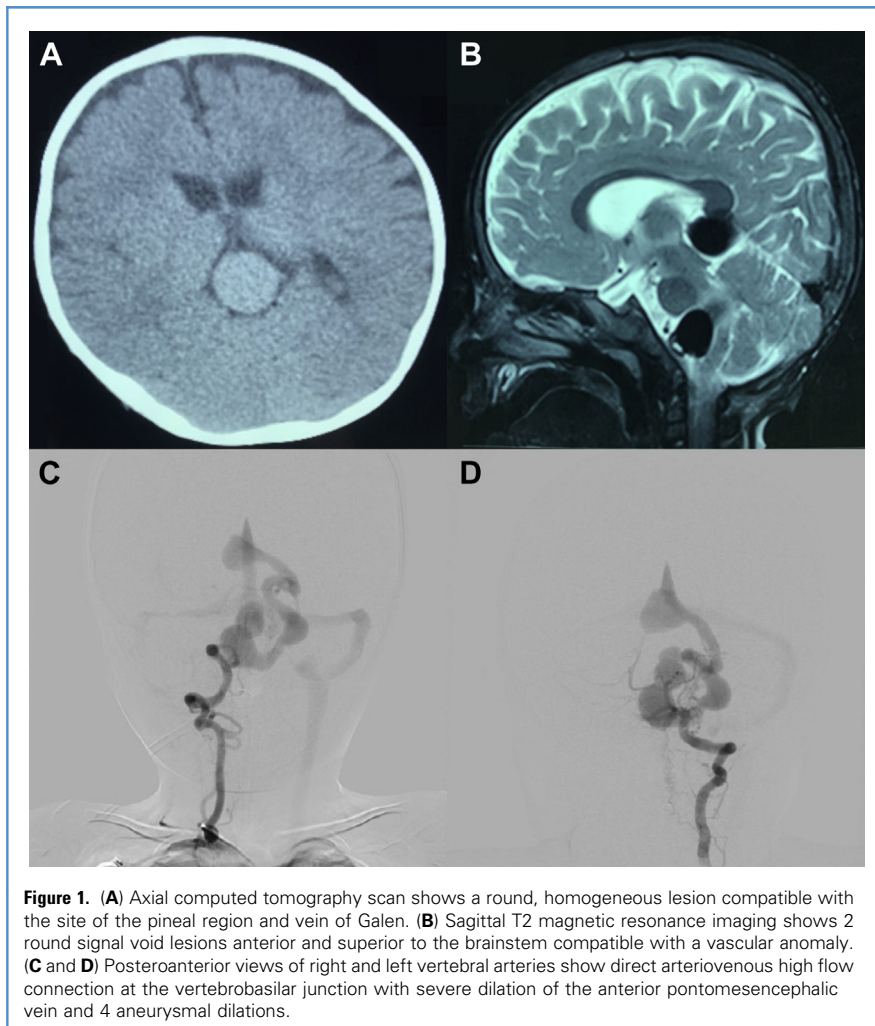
(A) Axial computed tomography scan shows a round, homogeneous lesion compatible with the site of the pineal region and vein of Galen. (B) Sagittal T2 magnetic resonance imaging shows 2 round signal void lesions anterior and superior to the brainstem compatible with a vascular anomaly. (C and D) Posteroanterior views of right and left vertebral arteries show direct arteriovenous high flow connection at the vertebrobasilar junction with severe dilation of the anterior pontomesencephalic vein and 4 aneurysmal dilations.
